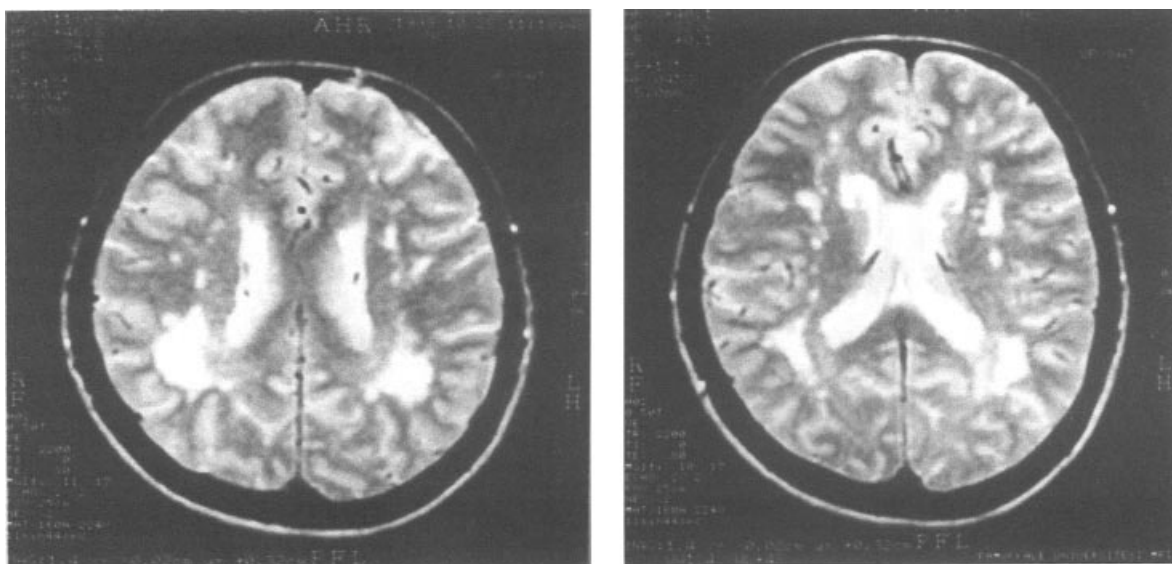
Axial T2-weighted MR scanning showing multiple periventricular and large biparietal hyper-intense white matter lesions.
